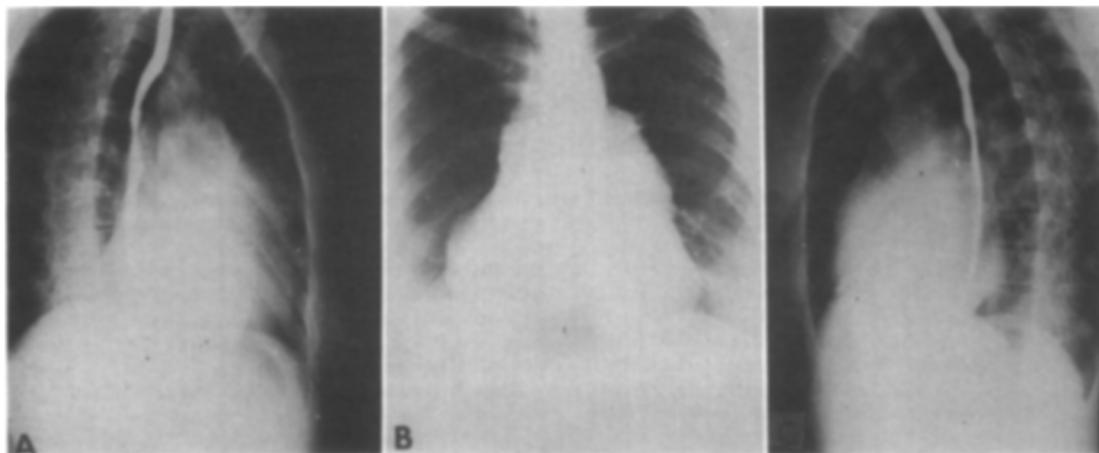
X-rays, June, 1965. A, Right oblique position, B, posteroanterior direction, and C, left oblique position.
